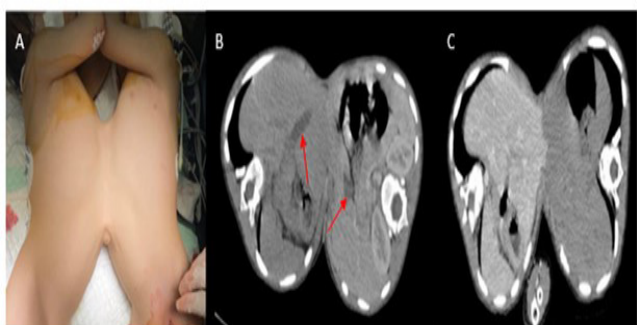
A. The external presentation of thoraco-omphalopus conjoined twins. B. The CT-scan revealed liver fusion occurring between segments 2-3 in Twin A and segments 2-4A in Twin B, each possessing its own portal and biliary drainage system (indicated by the arrow). C. The portal vein phase displayed no notable shared biliary or portal pedicles within the fused liver.
